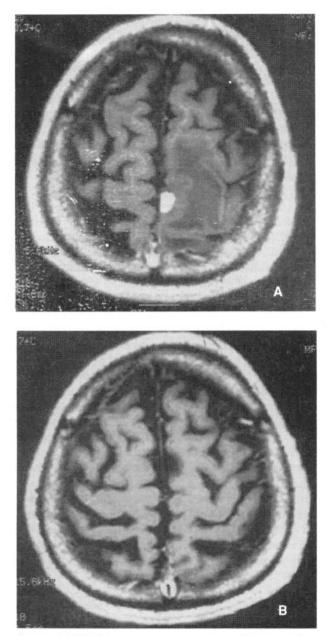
MRI images of a homogeneously enhancing metastatic lesion. -A; 5 days prior to radiosurgery
